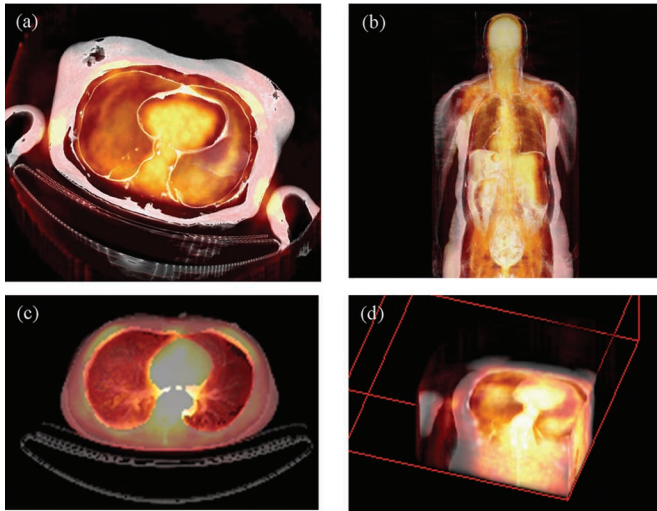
Various manipulations applied to PET/CT volume renditions. (a) Intensity thresholding of CT to show the lung boundary, fused with PET. (b) Window level applied to PET and intensity thresholding applied to CT images. (c) Window-level-adjusted CT (showing lung vasculature) fused with PET. (d) Clipped PET/CT (clipping box) with window-level adjustments.
